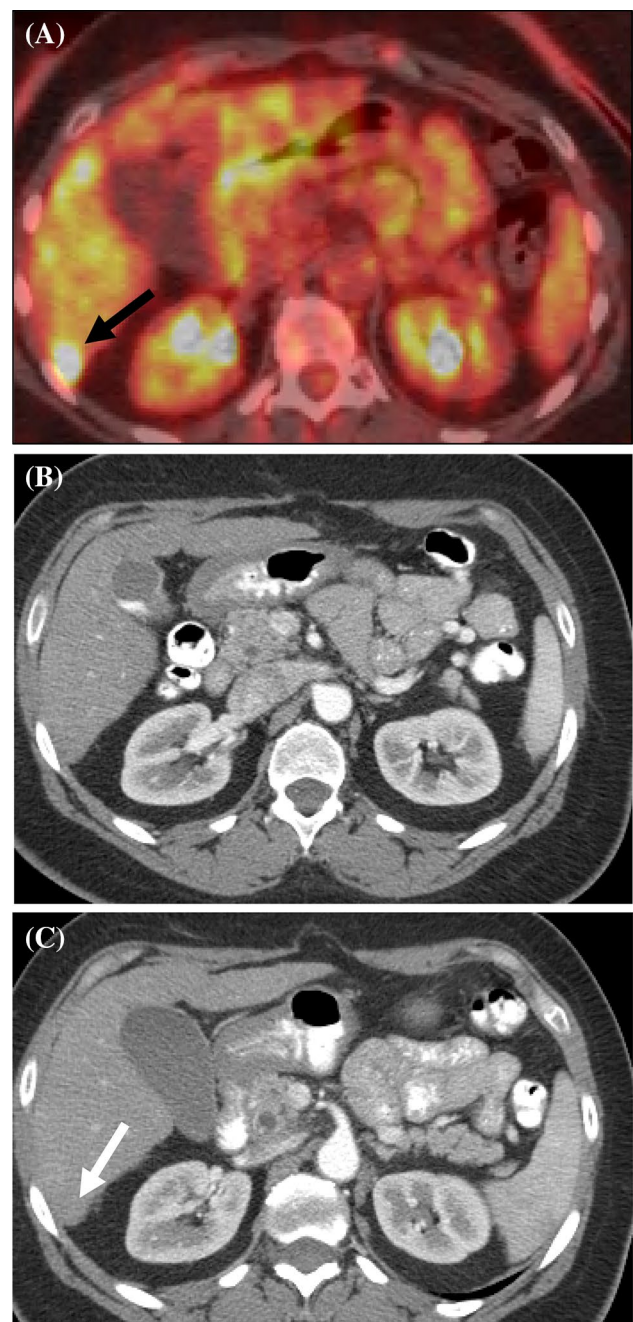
A 40-year-old male patient with previous history of right ACC resection. a PET CT shows a focus of avid FDG uptake (black arrow) in the liver. b Axial image from a concurrent contrast-enhanced abdominal CT b did not reveal any abnormality corresponding to the area of the avid FDG uptake. c Follow-up CT 3 months later; the area of abnormality detected in the previous PET CT is more appreciated by CT scan (white arrow)
